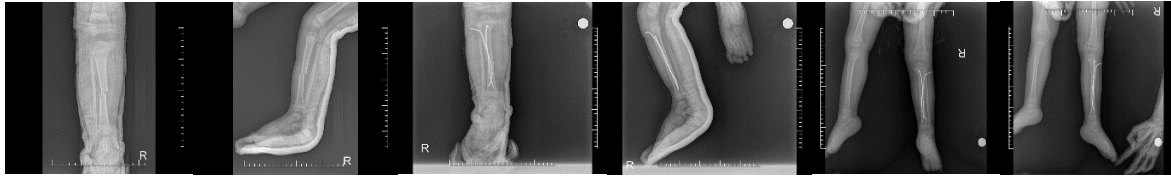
X-rays of tibia fracture with TEN applied, A) preoperative B) postoperative and C) final polyclinic control
